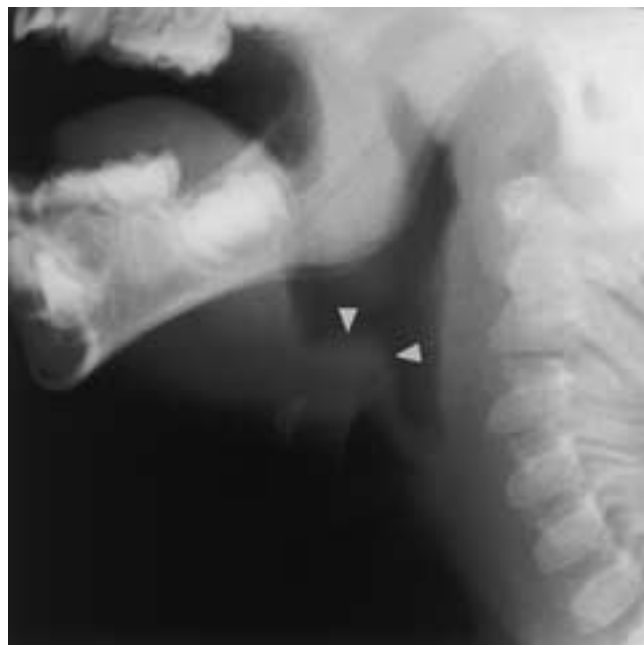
Streptococcal supraglottitis in a 3-year-old boy with throat pain and drooling. The lateral plain film reveals thickening of the epiglottis and aryepiglottic folds (arrowheads). There is some overdistention of the hypopharynx.
